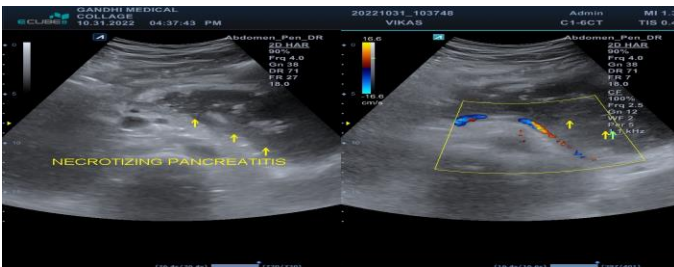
Ultrasound shows a focal ill-defined hypoechoic collection with internal debris in pancreatic neck and body region.
